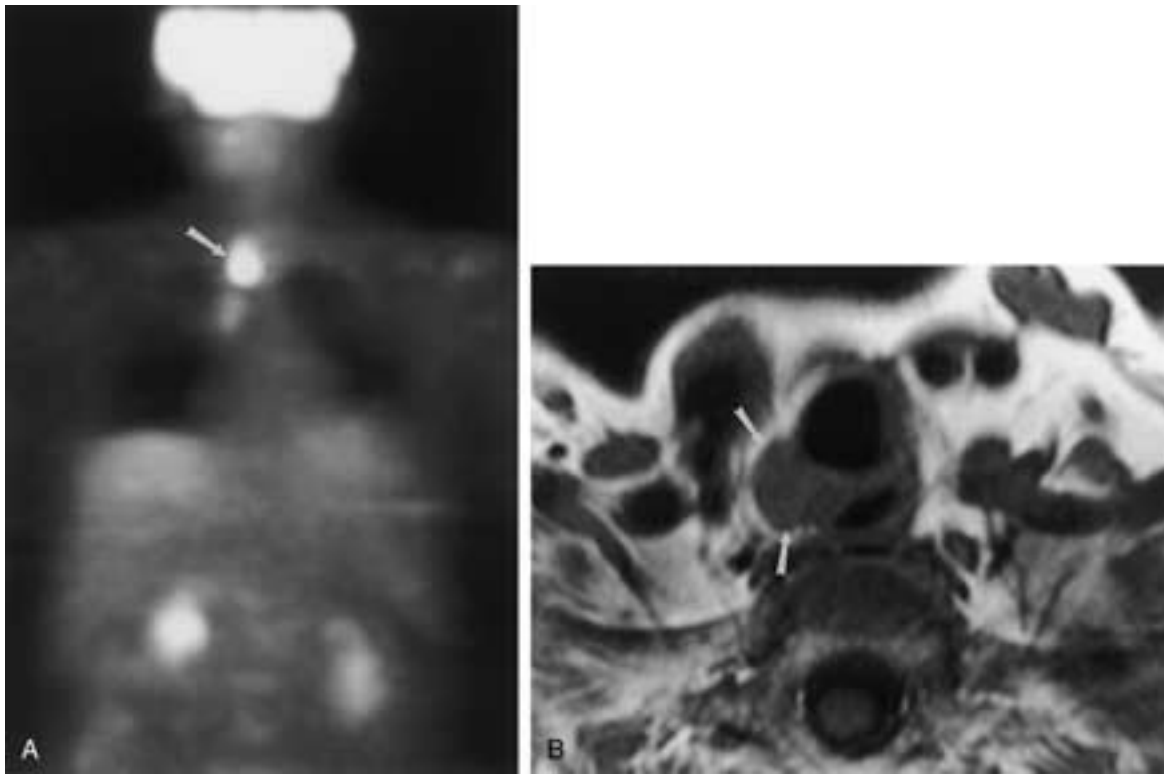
Recurrent thyroid cancer in a 64-year-old woman following thyroidectomy for papillary carcinoma, tall cell variant. A, ^{18}F FDG-PET image shows a region of intense radiotracer uptake (*arrow*) in the base of the right neck. B, Unenhanced axial T1-weighted MR image shows a corresponding soft-tissue mass in the right tracheoesophageal groove (*arrows*), confirmed to be recurrent tumor at surgery.
